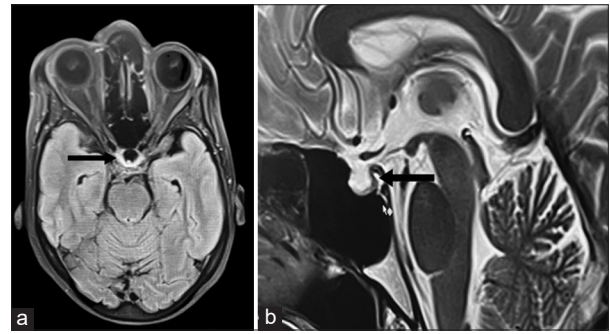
(a) T1-weighted magnetic resonance imaging (MRI) brain image showing empty sella; (b) T2-weighted MRI brain image showing empty sella.
